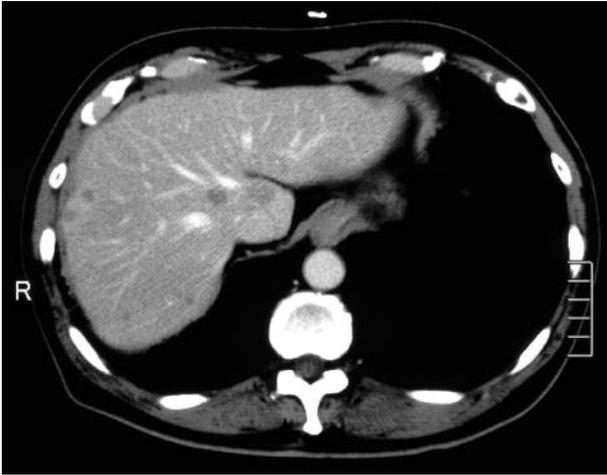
Computed tomography (CT) showed multiple hepatic metastases in the hepatic lobes before the chemotherapy with S-1 and CPT-11.
